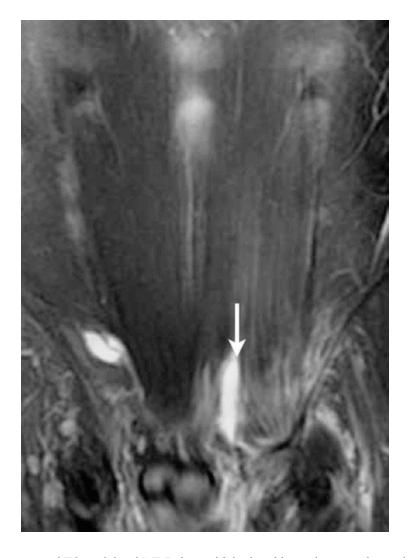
Coronal fat-suppressed T2-weighted MRI shows high signal intensity area due to left rectus abdominis
